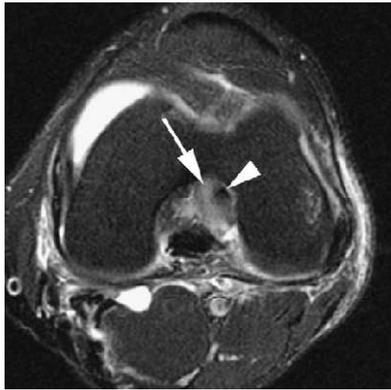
Partial-thickness ACL tear on corresponding axial T2-weighted MR imaging in same patient as in Fig. 19. Increased signal within the ACL AMB (arrow) with residual intact fibers indicates partial-thickness tearing. The adjacent PLB (arrowhead) has normal low signal intensity.⁽¹²⁾
